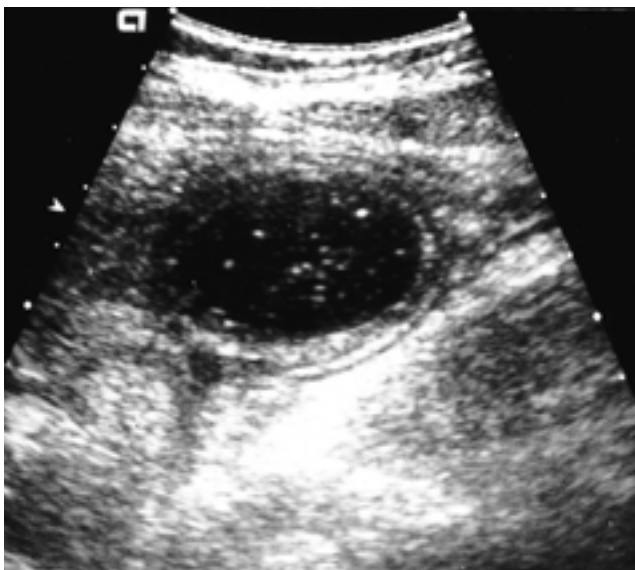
Transverse sonogram of upper abdomen shows a round cystic mass with internal echo that has a well defined, thin echogenic margin in the colonic lumen.
